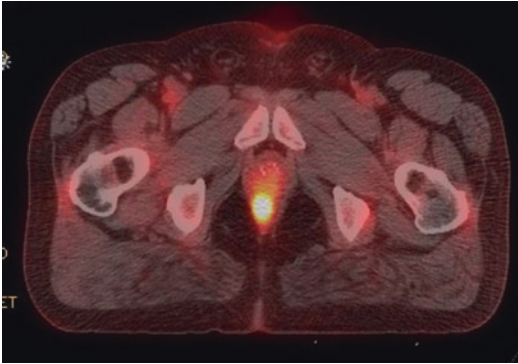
PET/CT demonstrating distal anal canal carcinoma
